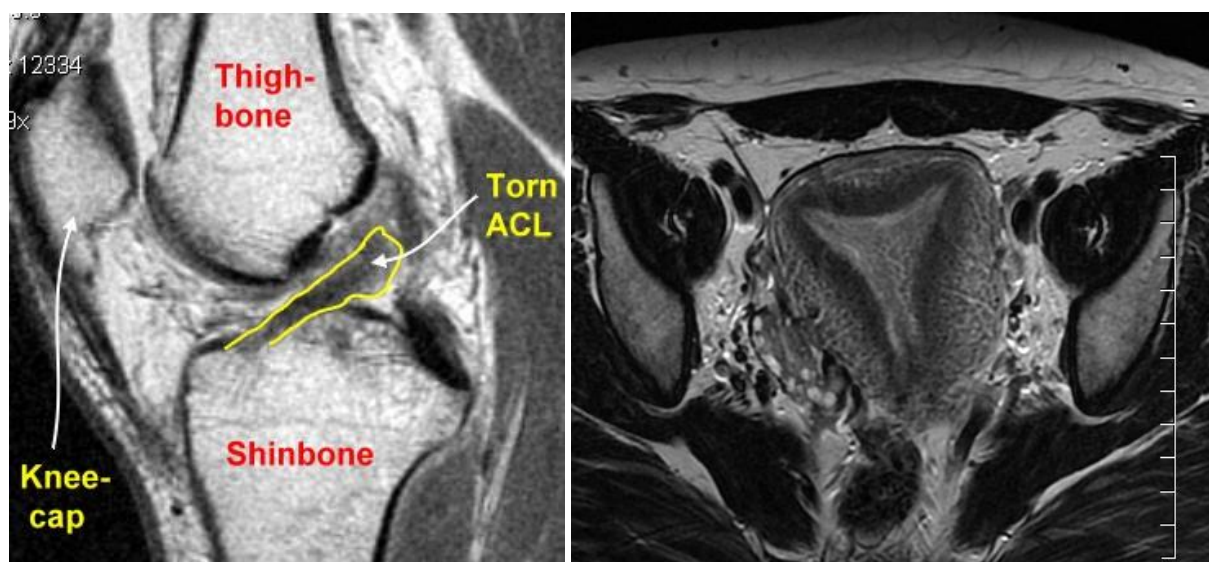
MRI of knee & pelvis.
